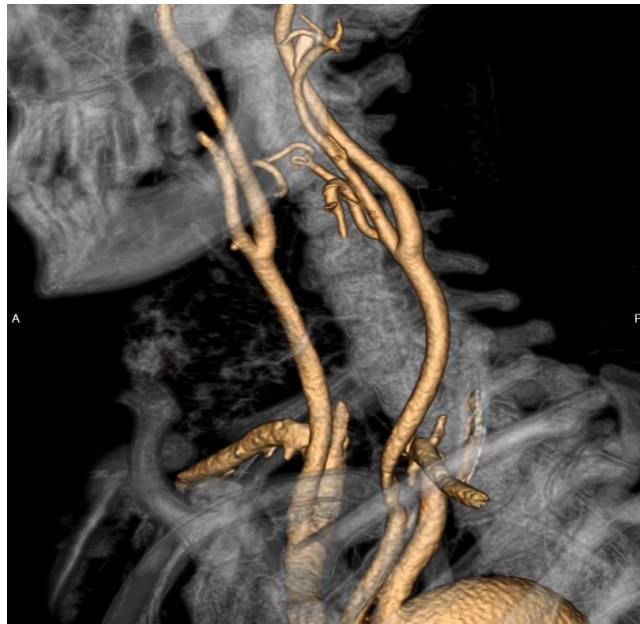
Computed tomography angiography of the neck depicting the absence of abnormal tumor vascularization.
